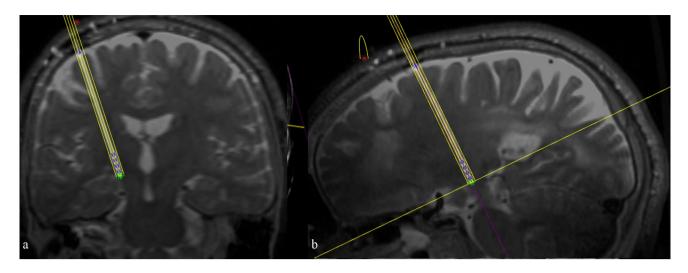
T2-weighted MRI coronal (a) and sagittal (b) sections representing the trajectory plans of patient no. 2
